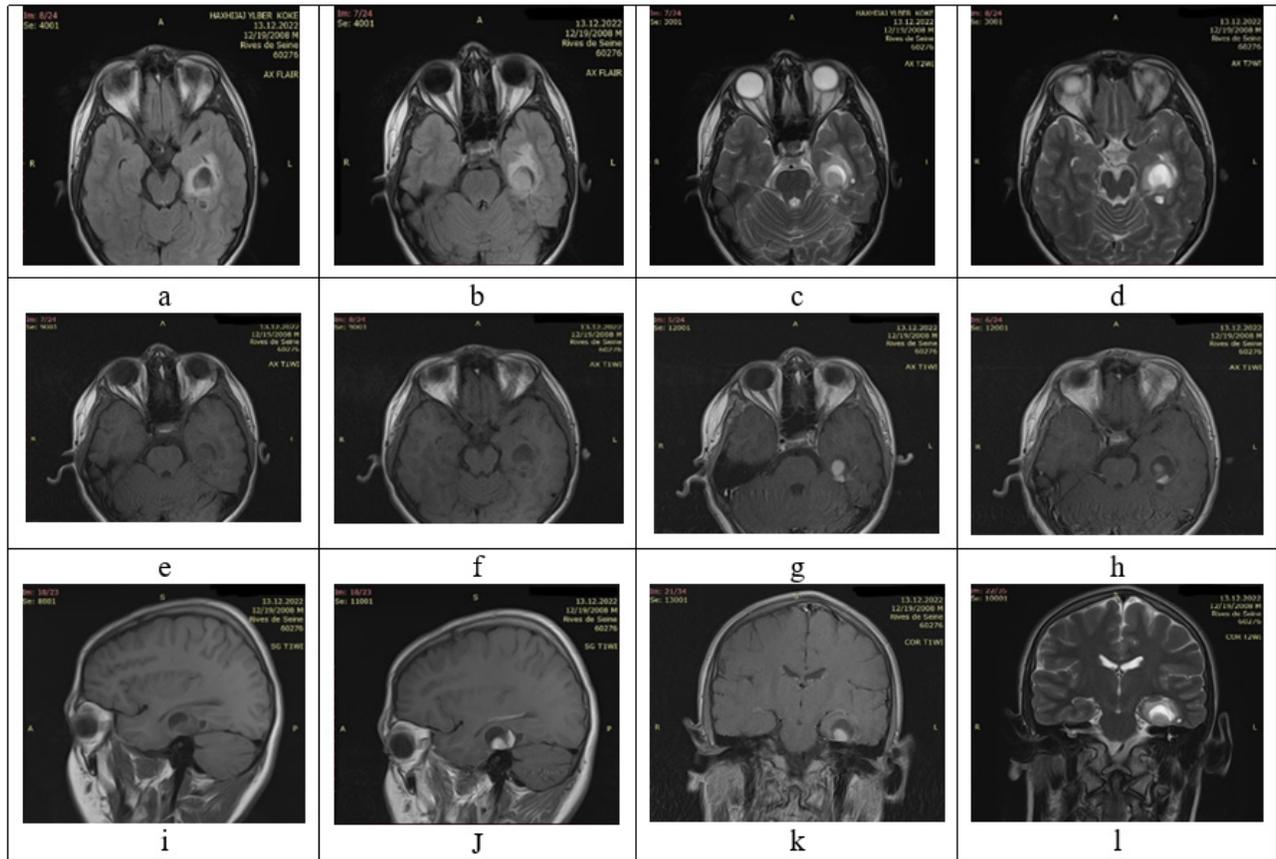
Preoperative images. MR images revealing a well-circumscribed, heterogeneous tumor with solid-cystic components in the left temporal lobe, approximately 26x20 mm in size, with peritumoral edema presented on axial Flair (a,b), on axial T2 images showing proximal cystic components 18mm very hyperintense (c,d). In T1, before the contrast, the cystic component is hypointense, while the solid part is isointense (e,f). After the gadolinium contrast application, there is the pathological enhancement of the solid component, mainly heterogeneous in the form of the nodule with a tracheal extension over the tentorium (g,h), while T1 in the sagittal plane before and after gadolinium, the pathological enhancement of the solid component is presented (i,j). Coronal T1 post-gadolinium (k) and coronal T2 (l) MR images.
